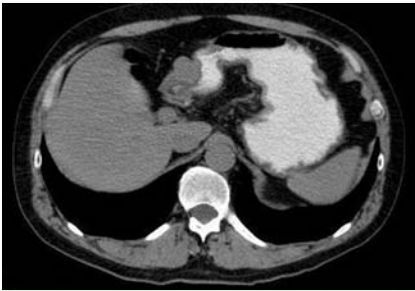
A computed tomography (CT) scan in a 54-year-old man with intermittent epigastric pain and dyspepsia showing a hyperdense mass in the gastric antrum.
